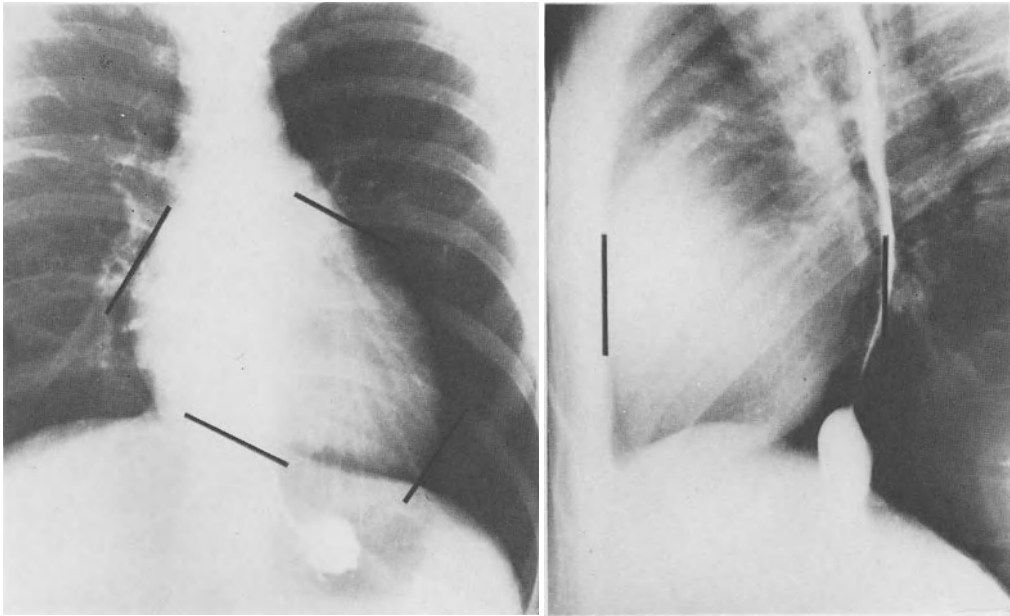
Supine biplane teleroentgenogram. Same patient as in Figures 1 and 2. In contrast to normal conventional chest X-rays of Figure 1, heart volume determined from these films was increased to 985 ml/1.73 m<sup>2</sup> (normal upper limit in females: 690 ml/1.73 m<sup>2</sup>)
